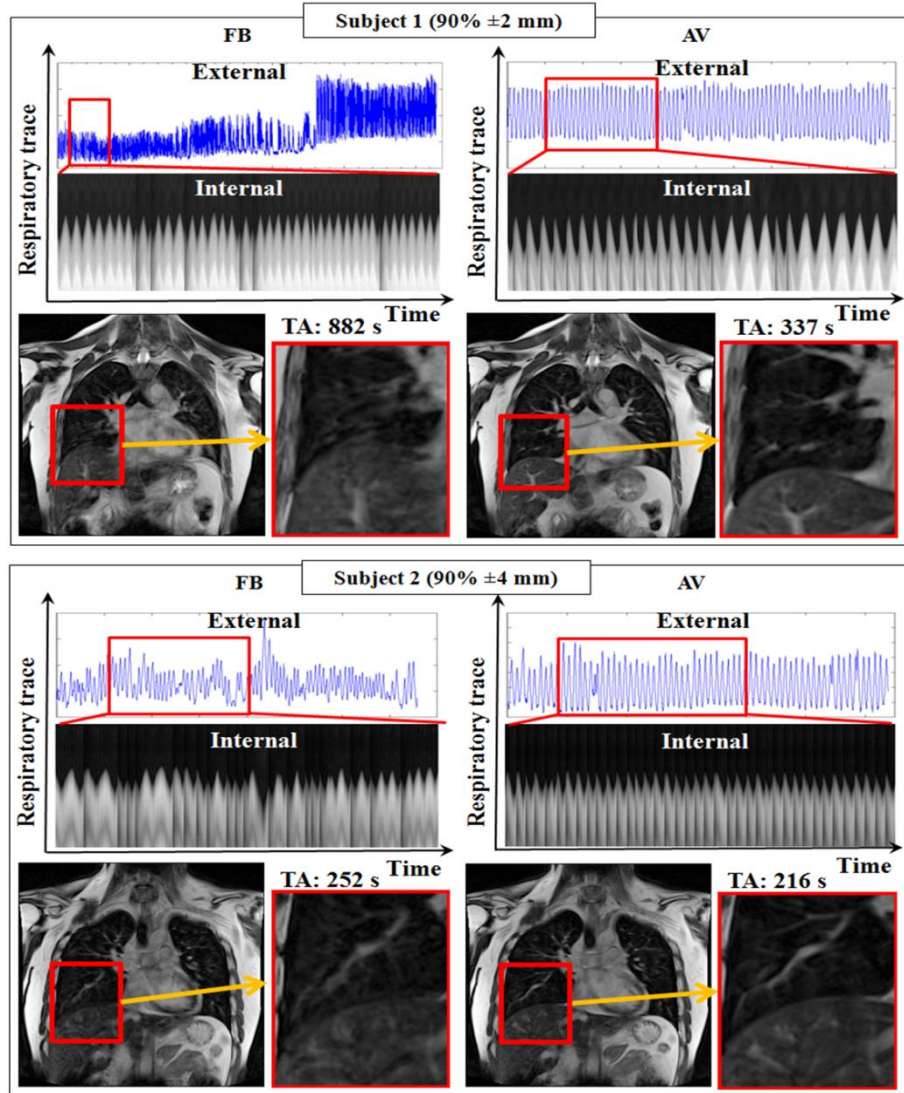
An example of improved image quality and total acquisition time (TA) when AV biofeedback was employed during gated 3D MR imaging for subject 1 (top) and subject 2 (bottom). Free-breathing results (left) and AV results (right) are shown. The external respiratory signal, internal diaphragm signal and images are shown. Gating was triggered at 90% of the breathing cycle (near maximum inhalation) with ± 2 mm (subject 1) and ± 4 mm (subject 2) gating thresholds. The regular external (abdomen) respiration correlated with the regular internal
